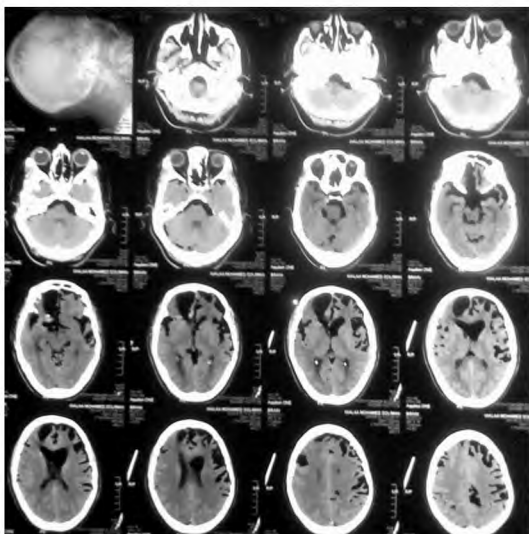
Postoperative CT scan. Left, immediate after deterioration of conscious level at PO 4. Right, after endoscopic repair and closure of defect.
